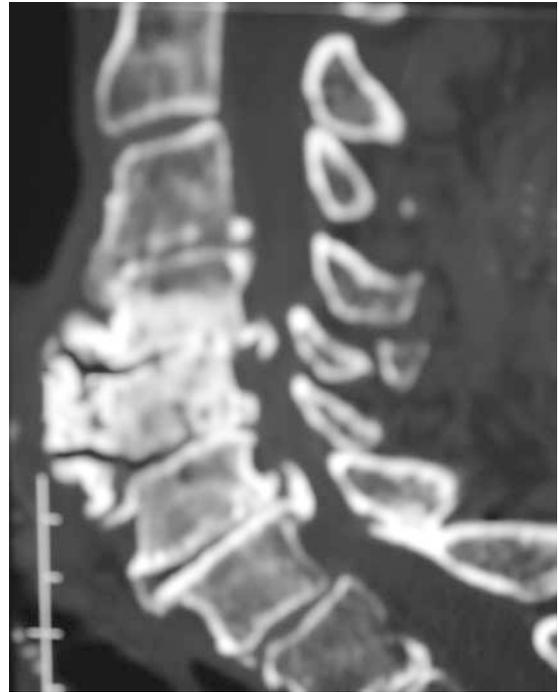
Multilevel OPLL is demonstrated on this paramedian sagittal 2D-CT scan extending from the inferior aspect of C4 through the superior aspect of C7. Also note the presence of advanced ossification of the anterior longitudinal ligament also involving the anterior vertebral bodies from C4, C5, C6
